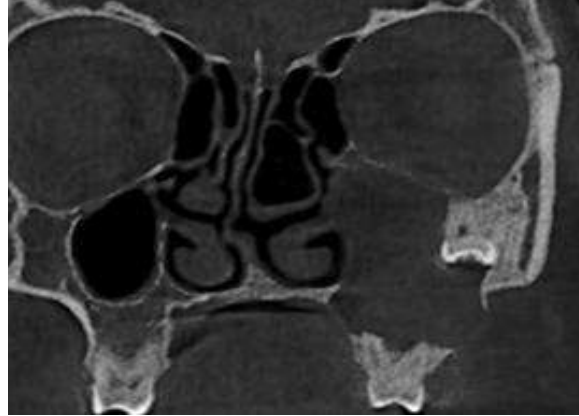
CBCT showing 28 in the medial wall of zygomatic bone.
